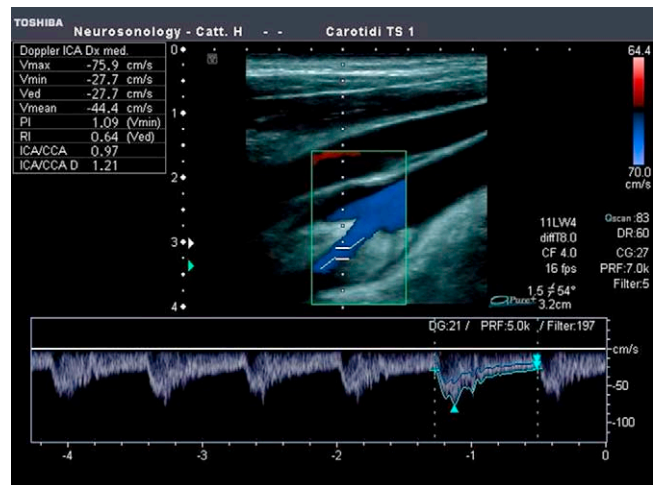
Extracranial carotid ultrasound examination. Right internal carotid artery and the flow waveform.
